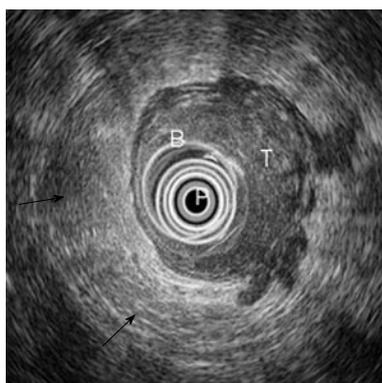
Stage T3 rectal cancer: Ultrasonographic view. Endoscopic ultrasound shows advanced cancer of the rectum with large hypoechoic and inhomogeneous thickening of the rectal wall, loss of the five-layered wall structure and deep infiltration of the perirectal fat. Endoscopic ultrasound with radial array transducer UM160 (5-20 MHz). B: Ballon; P: Transducer; T: Tumor; Black arrow: Perirectal fat.
